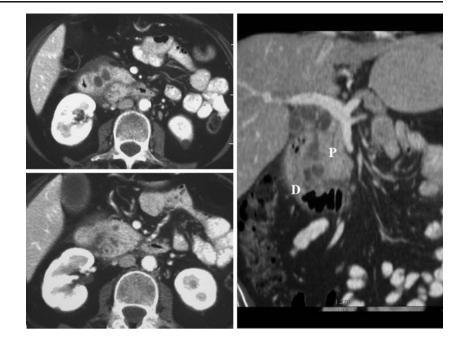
Groove pancreatitis. On the left, two axial enhanced CT scans showing fat stranding around pancreaticoduodenal area, mass-like occupation of the pancreaticoduodenal groove, duodenal wall thickening, and the presence of small cysts. According to the most accepted theories, they represent cystic dystrophy of a heterotopic pancreas in the duodenal wall. On the right, enhanced CT coronal reformation depicts the cystic and hypodense band between the pancreas (P) and the second portion of the duodenum (D)
